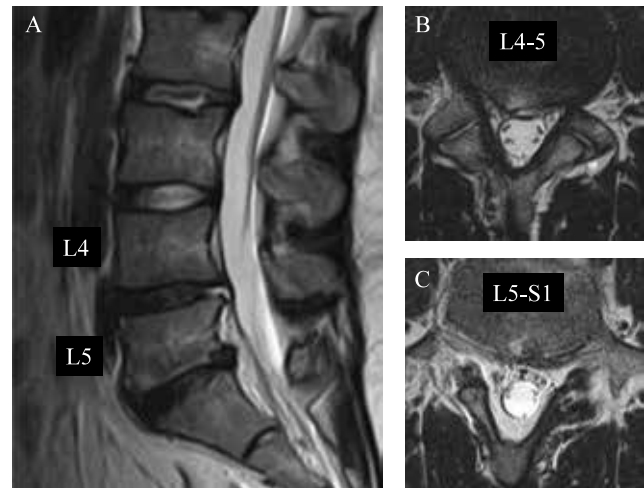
Preoperative sagittal (A) and axial T2-weighted magnetic resonance scans at L4-5 (B) and L5-S1 (C) demonstrating mild disc degeneration at both levels but no evidence of slip and no central or foraminal stenosis.
